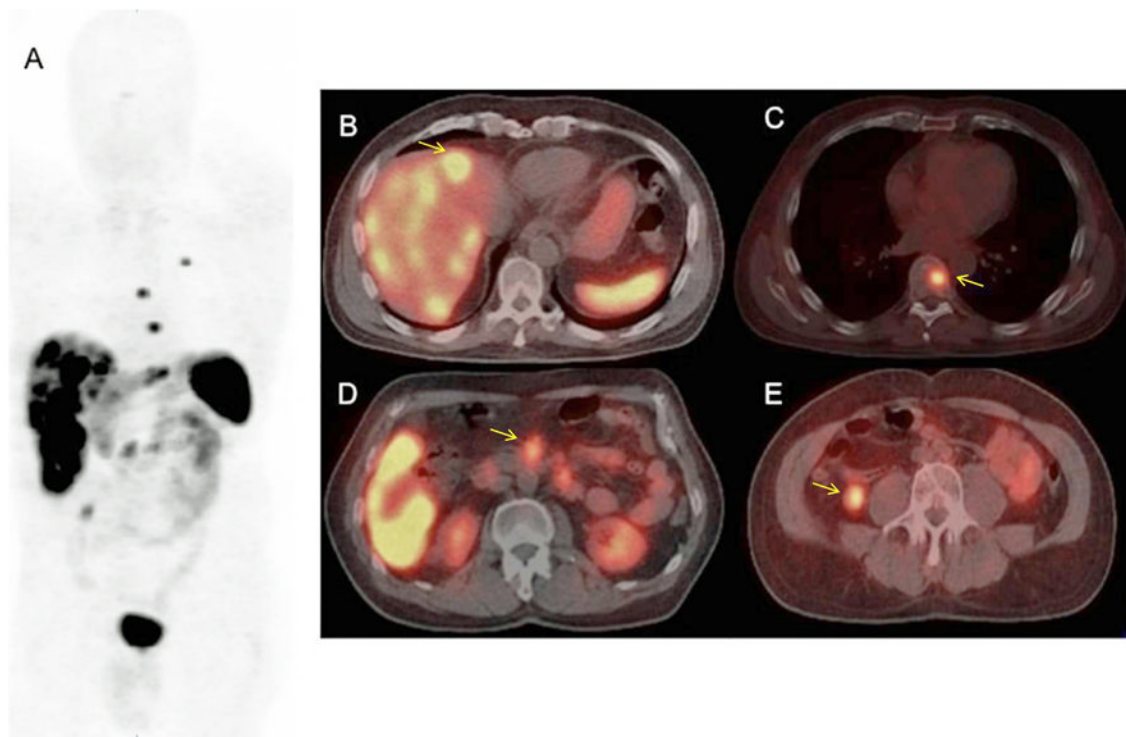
(A–E): ^{68}Ga -DOTATOC whole body PET (maximum intensity projection; Figure 1A) and select PET-CT images (Figure 1B–E) of a subject with widespread metastatic neuroendocrine tumor. Note the multiple liver lesions (Figure 1B; arrow), thoracic spine lesion (Figure 1C; arrow), paraaortic nodal lesions (Figure 1D; arrow) and an ileal small bowel lesion in the right lower quadrant (Figure 1E; arrow). The ileal primary lesion, which was subsequently confirmed surgically, was not detected prospectively on the ^{111}In -Octreotide scan obtained prior to ^{68}Ga -DOTATOC study.
